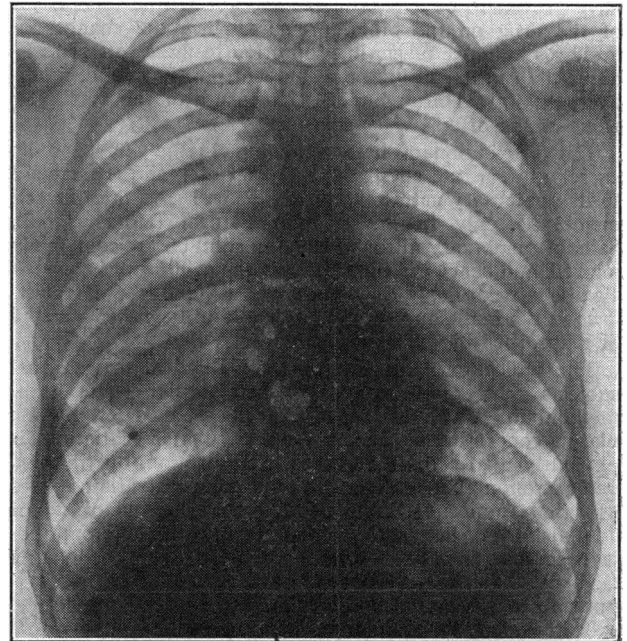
Case 1. X-ray film taken on August 10, 1950.
